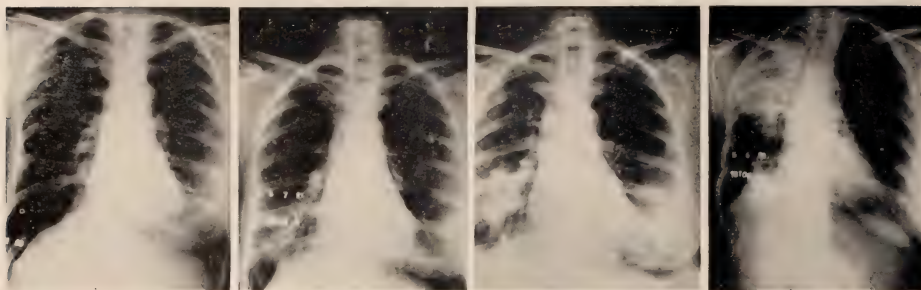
Case No. 14610—Mrs. J. F. A.—(1) Roentgenogram made at time of patient's admission before treatment was given, showing some increase in the right hilum. (2) First examination, showing increased density in the right lower lobe with limitation of movement of the inner half of the diaphragm.
